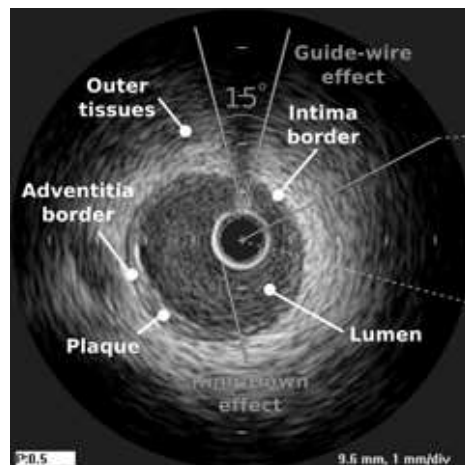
Intravascular Ultrasound
